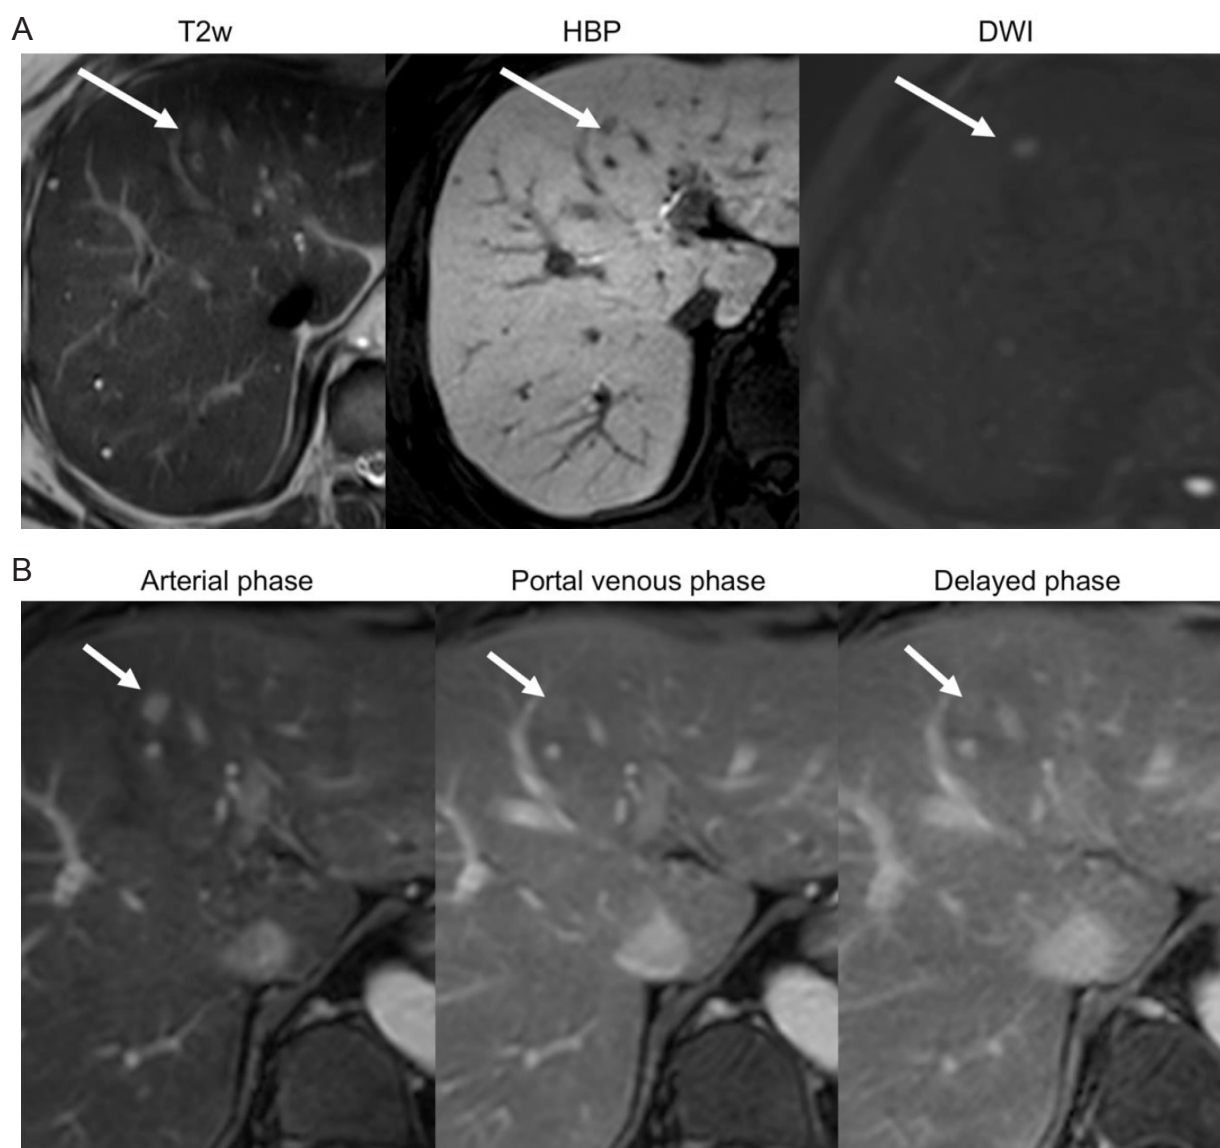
(A) Positive HBP-AMRI examination: 53-year-old male with chronic hepatitis B without cirrhosis. Images show an 8 mm HBP defect in segment 4, with mild T2 hyperintensity and restricted diffusion (arrows). On follow-up extra-cellular contrast MRI dynamic images (B) the lesion exhibits nonrim arterial phase hyperenhancement and capsule. An HCC was confirmed after lesion resection. HBP: hepatobiliary phase; AMRI: abbreviated magnetic resonance imaging; HCC: hepatocellular carcinoma
